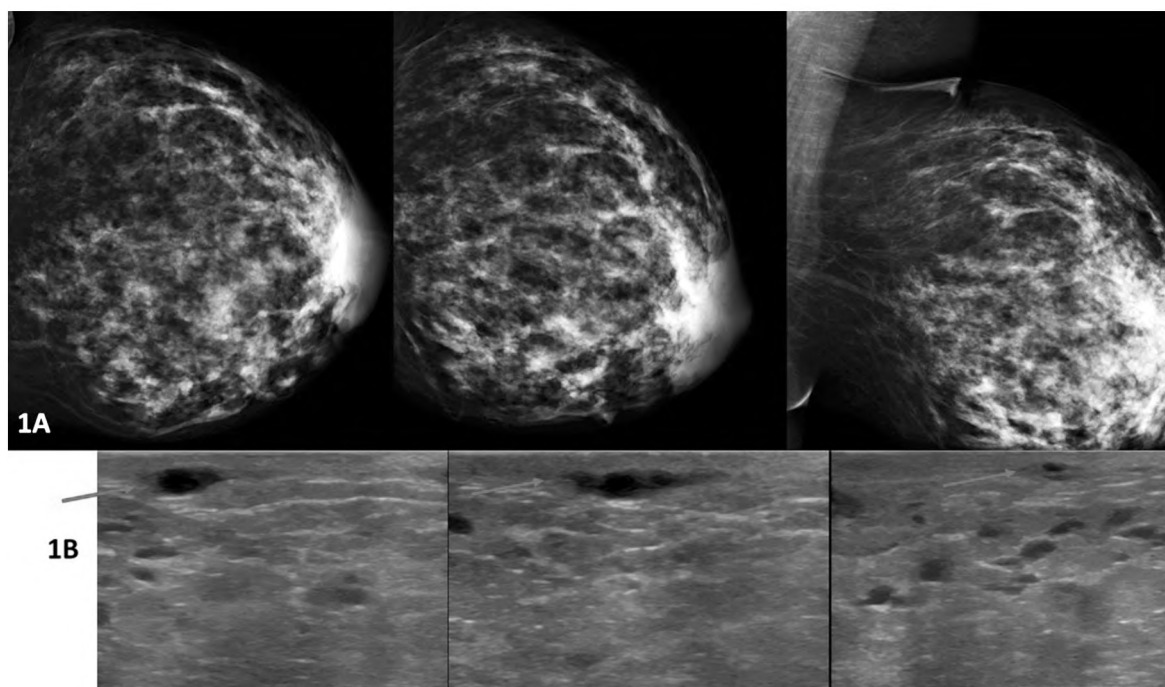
42 year old with history of minor trauma 10 days earlier presented with a left breast palpable painful mass. (A) Left breast craniocaudal and mediolateral oblique mammograms show a linear density at upper outer quadrant. (B) Sonogram reveals a hypoechoic tubular structure of varying width (arrows) that corresponds to the palpable abnormality.
